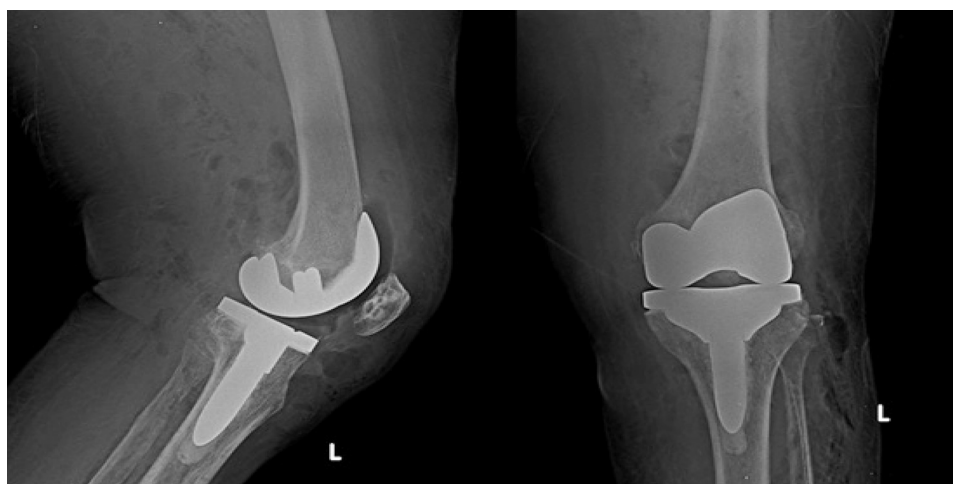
Radiographs in antero-posterior and medio-lateral views depicting femoral and tibial components following TKA with no obvious bony abnormalities but shows soft tissue edema surrounding the implants
